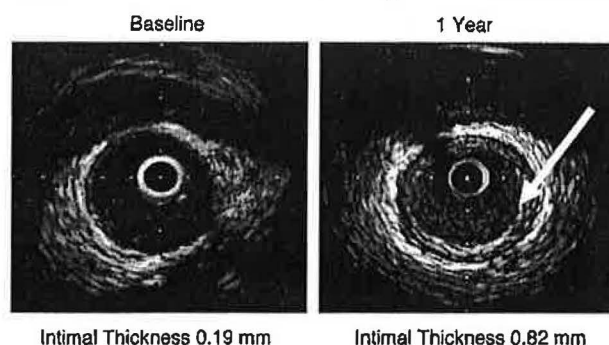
Increased intimal thickness after 1 year post-transplant as assessed by intravascular ultrasound. Arrow points to increased intimal thickness as compared to baseline seen on left panel. From (128)
